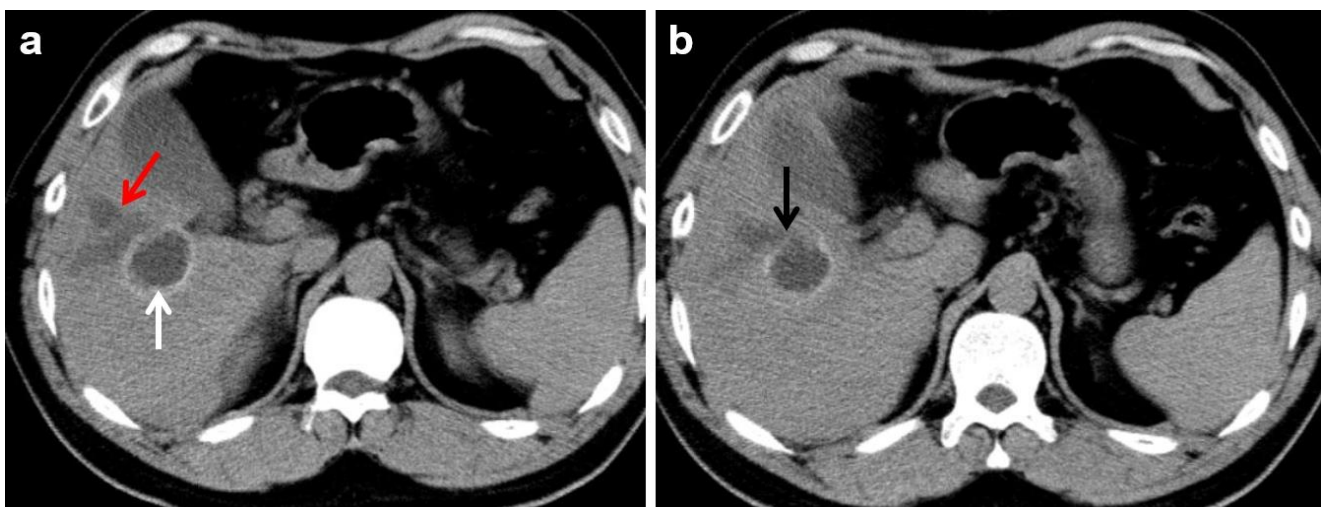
Axial sectional images on CT of the abdomen show hydatid cyst with calcified wall (white arrow) and biliary tract dilatation (red arrow) adjacent to the cyst (a). A fistula is visible between the cyst and the biliary tract (black arrow) (b)
